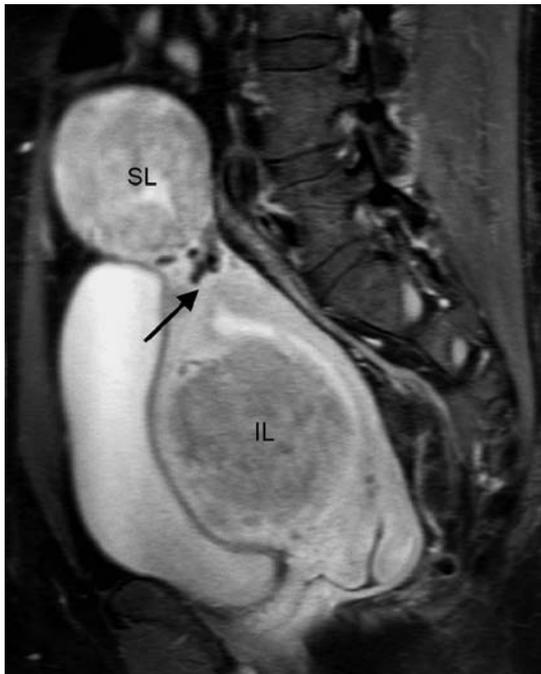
Bridging vascular sign in a pedunculated leiomyoma. T1-weighted contrast-enhanced fat-suppressed sagittal image depicts a large pedunculated subserosal leiomyoma originating from the uterine fundus. Flow-voids are seen within the vessel stalk (*arrow*). A second intramural leiomyoma in the anterior wall is seen displacing the endometrial stripe. (Reproduced with permission from [223])
